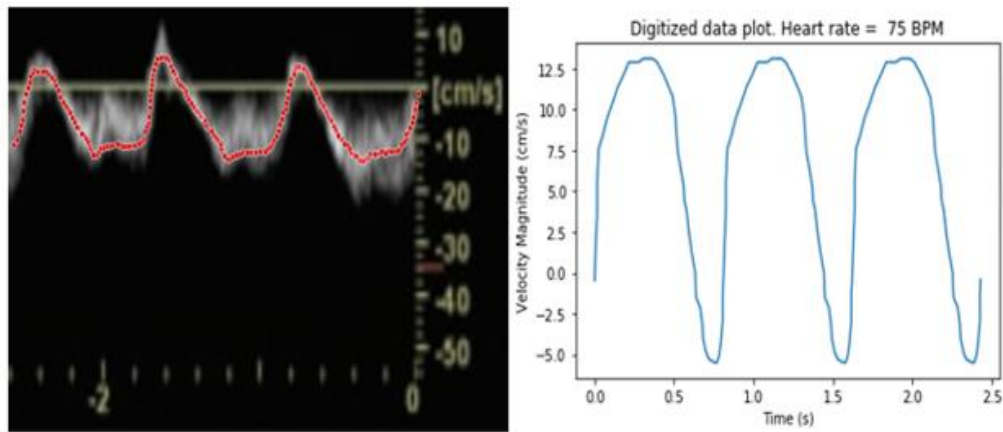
Digitization of velocity data from sonography. Red dots manually placed and generated .csv file used to create plot on right.
